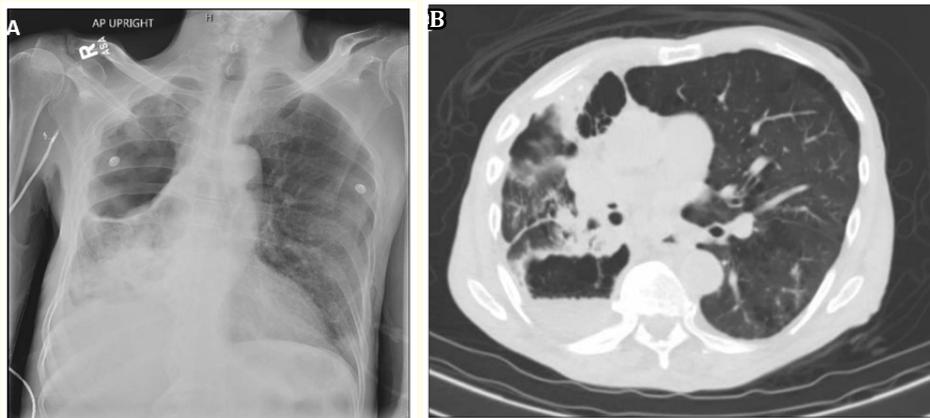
A) Antero-posterior chest x-ray showing a large cavity in the right upper (RU) lobe. B) CT scan of thorax showing a cavitory lesion in the RU lobe with consolidation and cavitation in the lower and the middle lobes, plus mediastinal lymphadenopathy and emphysema.
